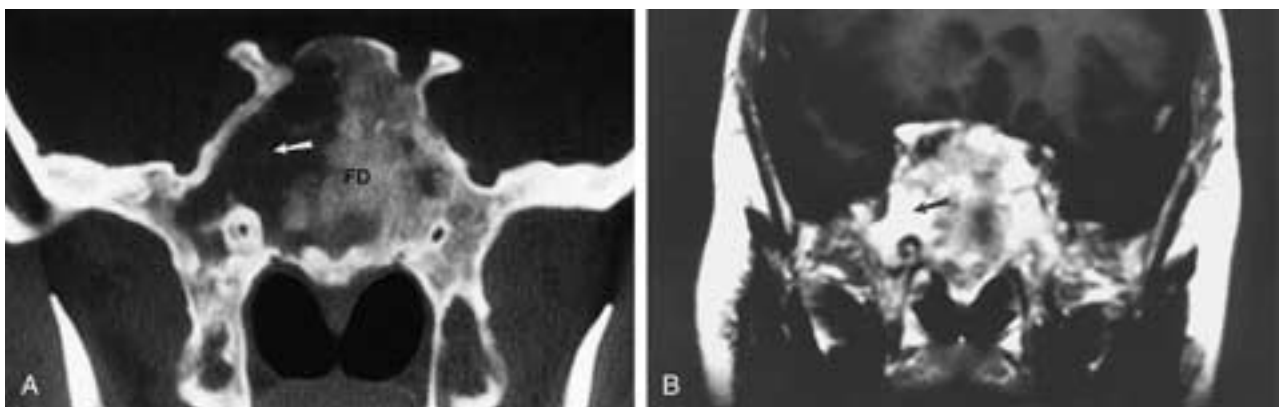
Fibrous dysplasia A, Fibrous dysplasia with low-density area on CT. The fibrous dysplasia (*FD*) fills and expands most of the body of the sphenoid. There are areas of low density (*arrow*), which could represent either cystic components of the fibrous dysplasia or areas of obstructed secretions because of the sinus mucosa. B, Coronal T1-weighted MR image shows high signal intensity consistent with the cystic portion of the fibrous dysplasia. However, note that this area extends between the Vidian canal and the foramen rotundum, which would be the usual position of a laterally extending air cell.
